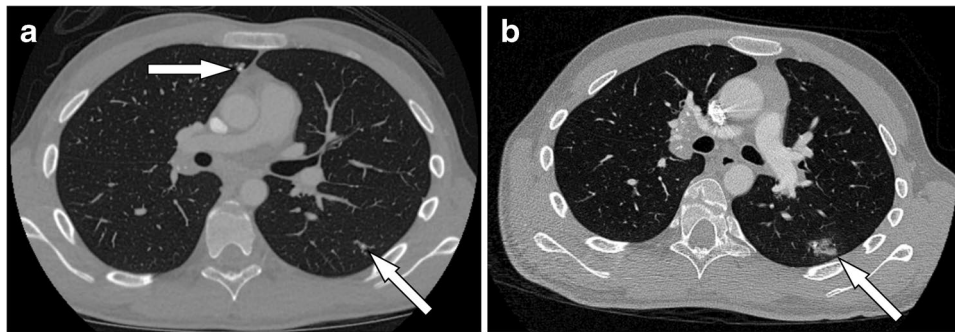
17-year-old boy with prior histoplasmosis infection. a Axial chest CT image with IV contrast material shows centrally calcified nodules in the left lower lobe and right upper lobe (arrows). b Axial chest CT image with IV contrast material obtained 7 weeks later for
